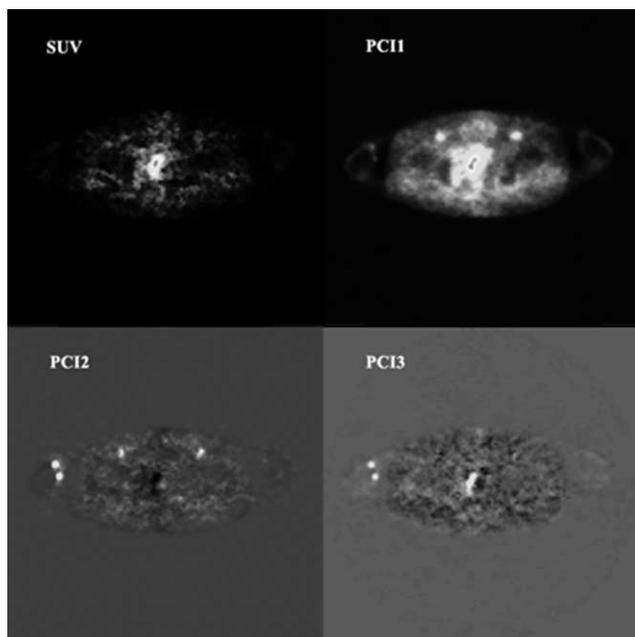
SUV image (upper left) and the corresponding principal component images PCI1 (upper right), PCI2 (lower left) and PCI3 (lower right). PCI1 looks like a high contrast summed SUV image. PCI2 is dedicated to the vascular component and PCI3 to the tumor component.
